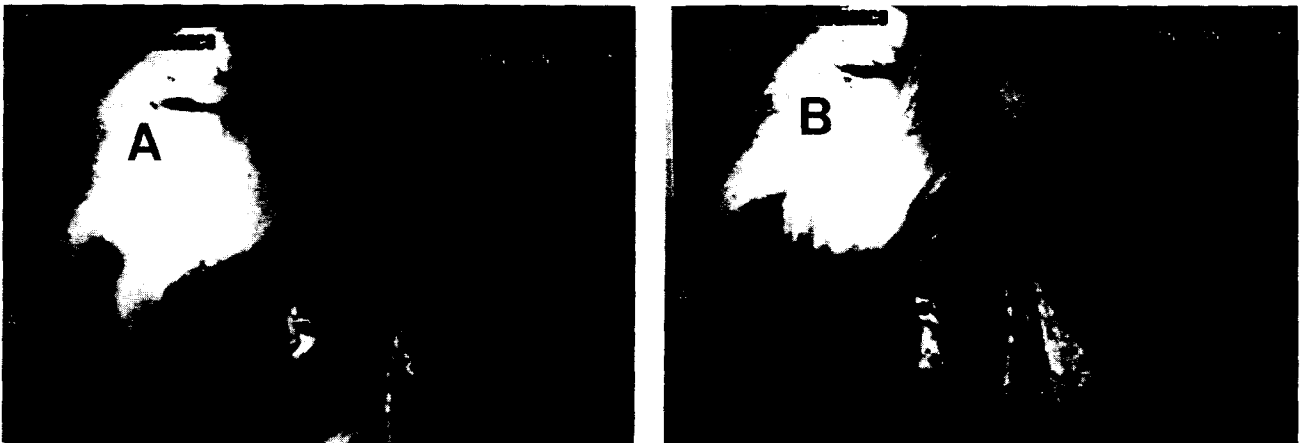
Folded disc configuration in closed (A) & open (B) mouth seen by T1-weighted sagittal MR image of anterior displacement without reduction of the temporomandibular joint in 26-years female.
